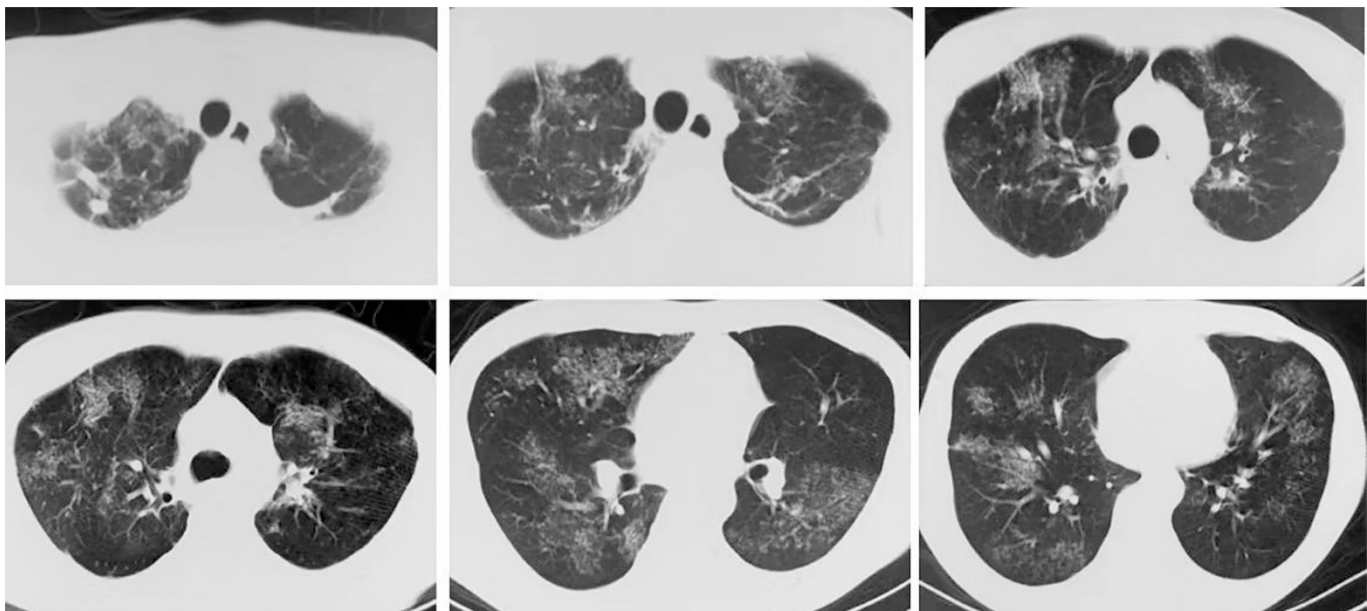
Chest CT for reoccurrence in 2019.
